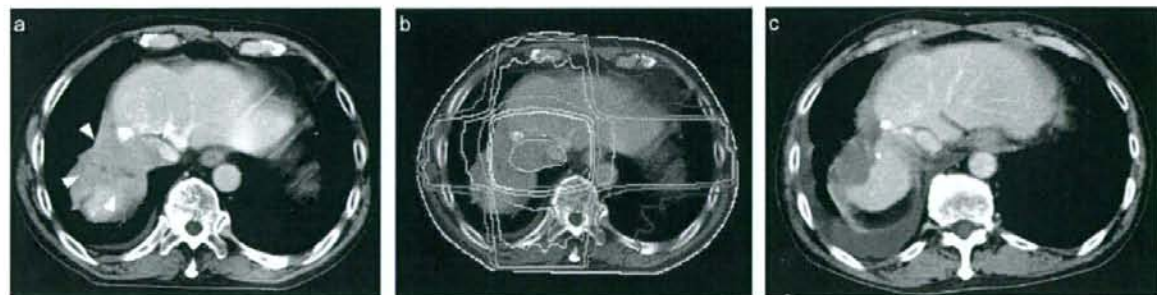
A representative case of a 72-year-old male with Child–Pugh class A hepatic function (case 12 in the Tables 1 and 2). (a) Before radiotherapy, the tumor located in S7 extended to IVC and the intraluminal space was narrow in the CT images. The tumor was indicated by the red arrowhead. (b) Dose distribution of the treatment plan. A total tumor dose of 50 Gy was delivered in 25 fractions by a dynamic conformal arc with four static fields. (c) Three months after radiotherapy. S7 tumor disappeared and no enhancement defect was observed within IVC, and the treatment response was judged as a complete response. The patient died of hepatic failure 13.7 months after irradiation. The irradiated tumor had no sign of regrowth at the time of death. (A colour version of this figure is available as supplementary data at <http://www.jjco.oxfordjournals.org>.)
